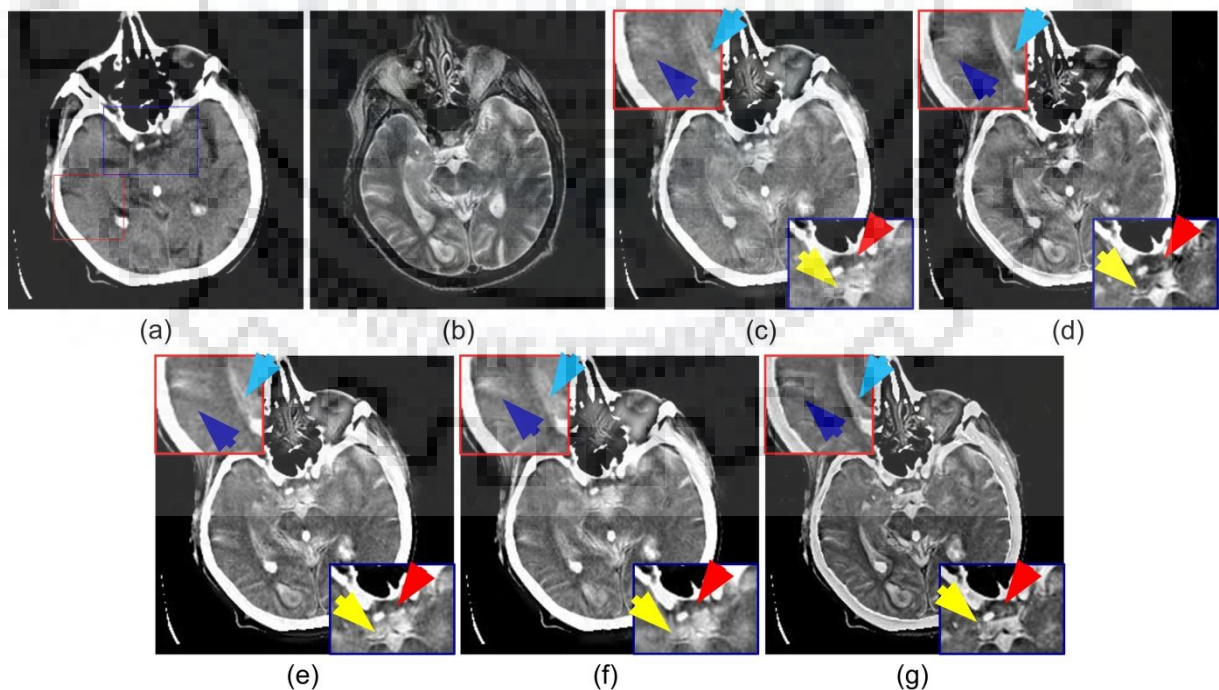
Comparative analysis of fusion results obtained for source (a) CT image (b) MR image, by (c) Ganasala and Kumar, 2016 [48] (d) Yang et al., 2017 [203] (e) Zhu et al. (HMSD-GDGF), 2018 [218] (f) C-MIF method (g) Proposed H-MIF method
